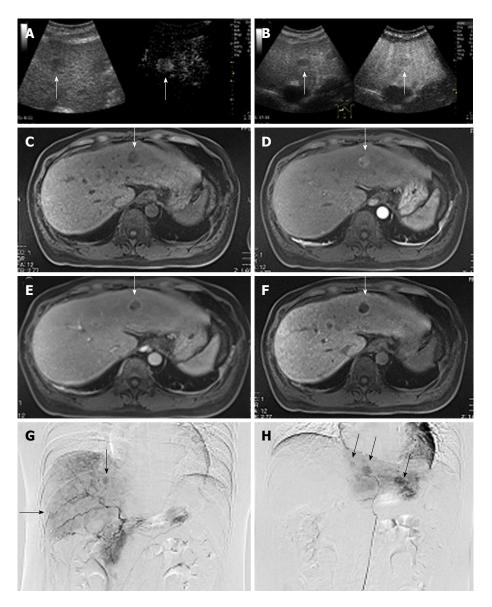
Images of Case 1. Contrast-enhanced ultrasonography. A: The vascular arterial phase; B: The Kupffer phase; EOB-MRI; C: T1-weighted MRI image; D: The arterial phase; E: The portal phase; F: The hepatobiliary phase; G and H: Angiography. EOB-MRI: Gd-EOB-DTPA-enhanced magnetic resonance imaging.
